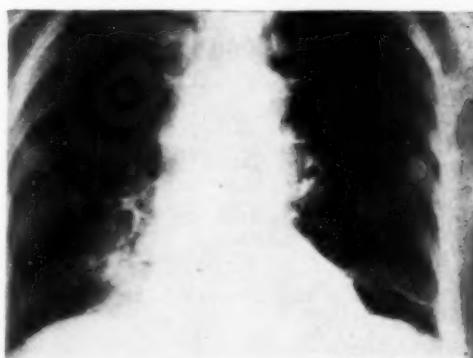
Case II: Chest roentgenogram showing lung metastases.
